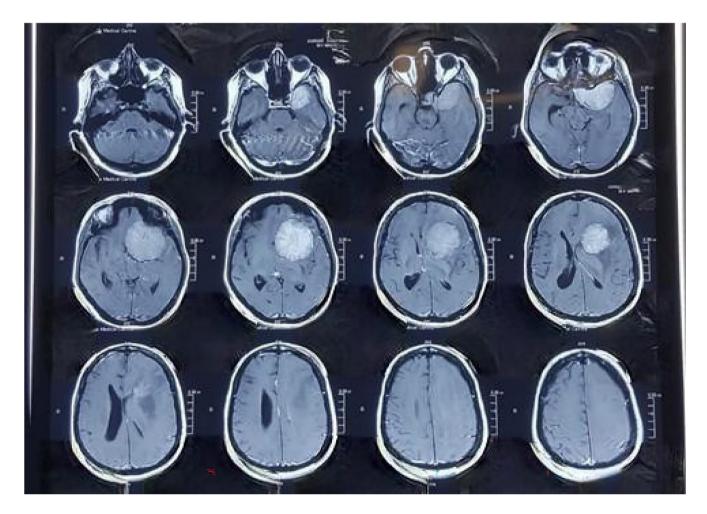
Preoperative axial magnetic resonance imaging brain of a patient with a large left sphenoid wing meningioma.
